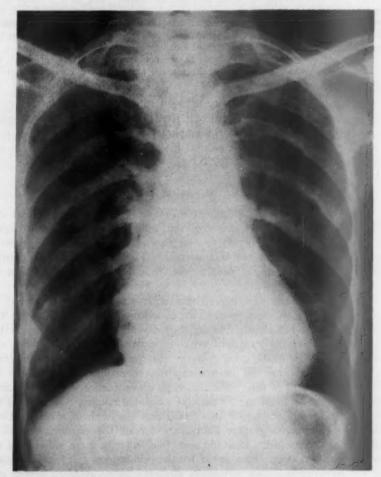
Case 6. Chest x-ray fwo years after onset of symptoms. Note erosion of inferior borders of ribs, indistinct infiltrate in right upper lung, and cardiomegaly.
